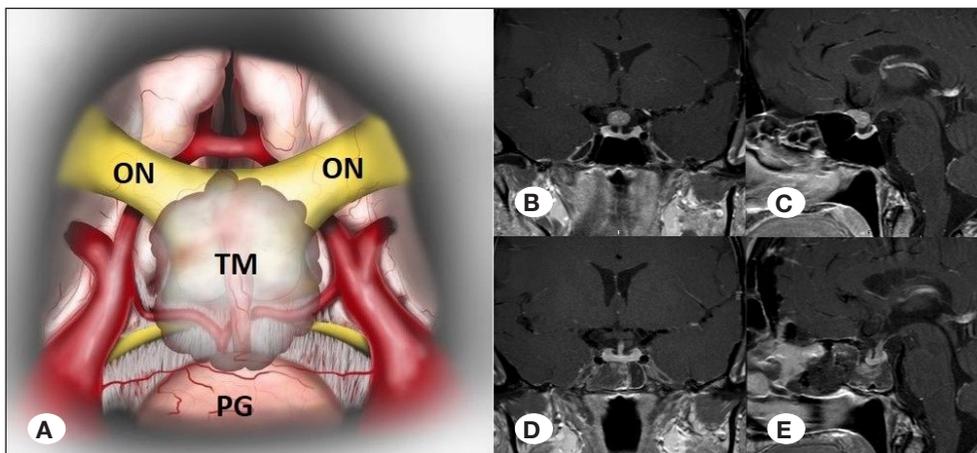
Tumor within the infrachiasmatic corridor and MR images. A) Tumor within the infrachiasmatic corridor. B) Preoperative coronal T1-contrast-enhanced MR image of patient with tumor within the infrachiasmatic corridor. C) Preoperative sagittal T1-contrast-enhanced MR image of patient with tumor within the infrachiasmatic corridor. D) Postoperative coronal T1-contrast-enhanced MR image of same patient E) Postoperative sagittal T1-contrast-enhanced MR image of same patient. TM: tumor, ON: Optic nerve, PG: Pituitary gland.
